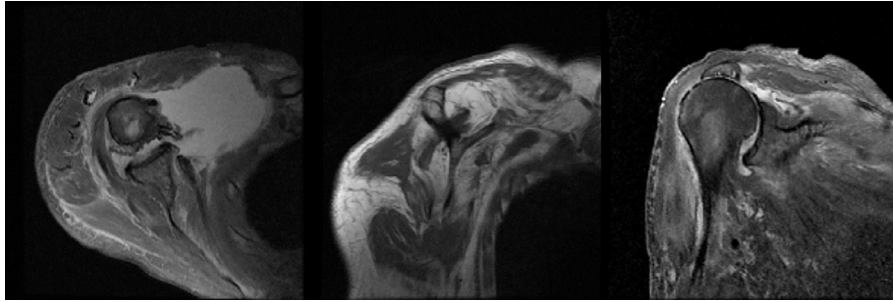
MRI images of irreparable rotator cuff tear and fatty infiltration of rotator muscles.
